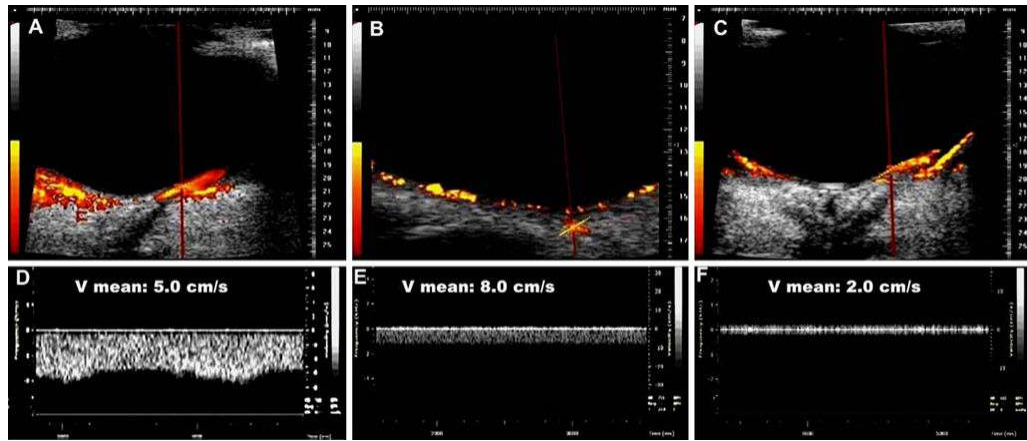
Combined power Doppler and spectral Doppler imaging of the choroidal vein (a, d), CRV (b, e), and branch retinal vein (c, f). Blood velocity in these veins is represented by the mean velocity (V_{mean}). Note the pulsatile waveform of the choroidal vein
